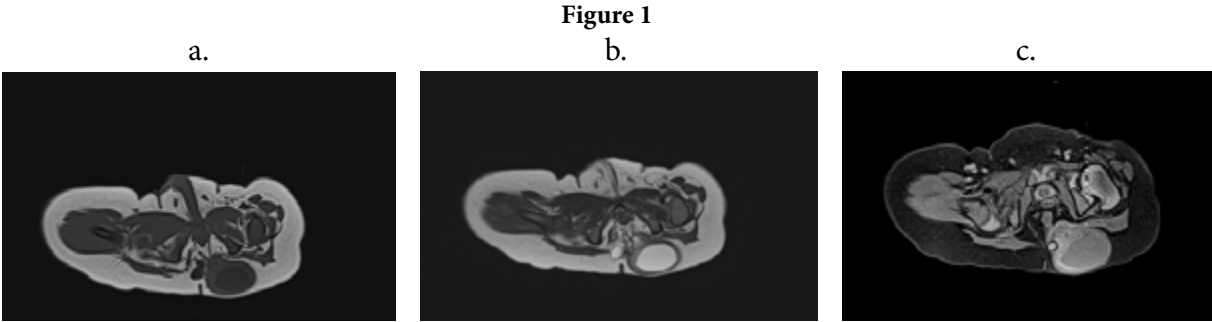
MRI of pelvis in neonate showing cystic, oval mass arising from the sacrococcygeal region on T1 axial plane (a) with predominantly hypo and iso signal components. T2 axial plane (b) showing hypersignal inner content with hyposignal thick wall, corresponding to fluid signal without any evidence of calcification (diamond shape showing the cystic component)
